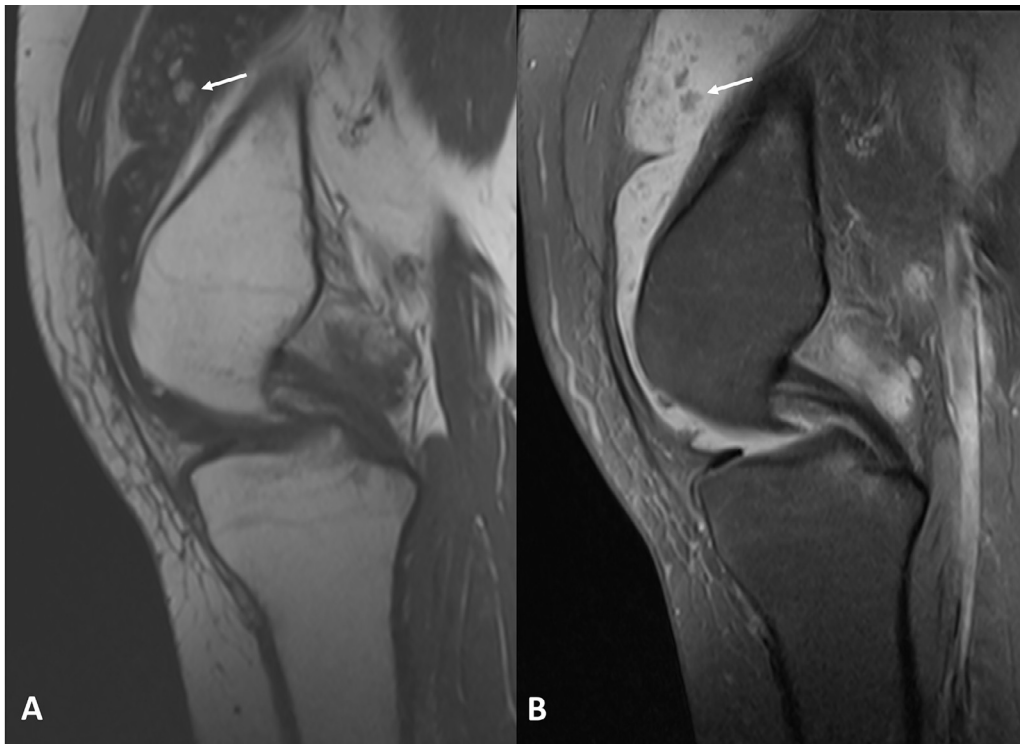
Sagittal T1 (A) and sagittal PD fat saturated (B) MRI sequences. There is a large knee joint effusion with synovial proliferation. Many of the synovial fronds demonstrate T1 hyperintensity (arrow) which suppresses on the fat saturation sequence (arrow).
